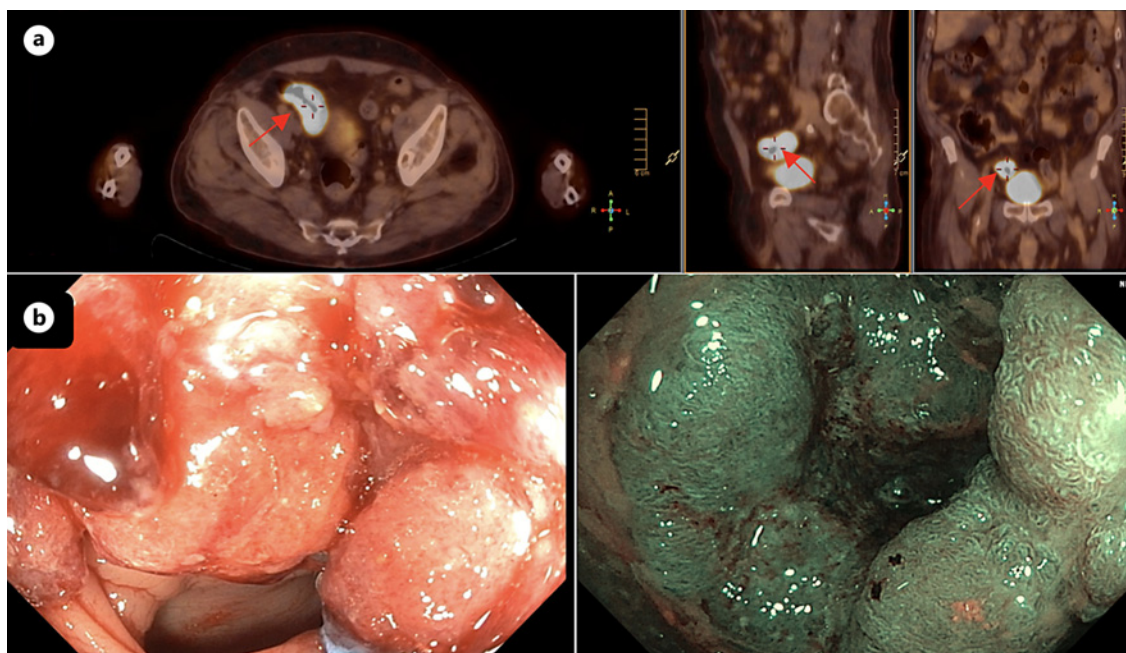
Seventy two-year-old man was submitted to 18Fluorine-FDG PET/computer tomography in the context of a hematological disorder. There was incidental FDG uptake in the right colon. The patient underwent colonoscopy, which showed an adenocarcinoma. a Fused PET/CT image showing
